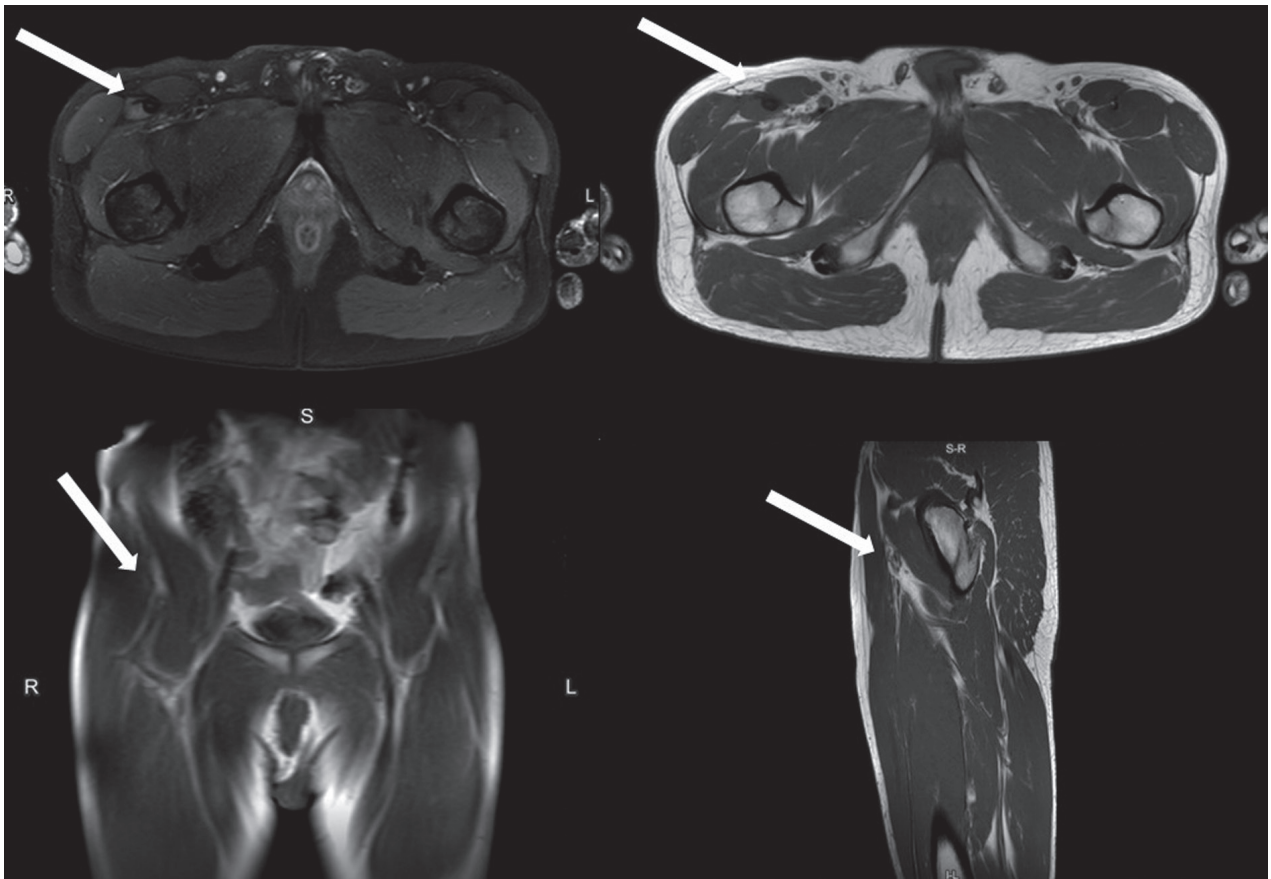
MRI 45 days following the infiltrative cycle with advanced signs of healing (arrows)
